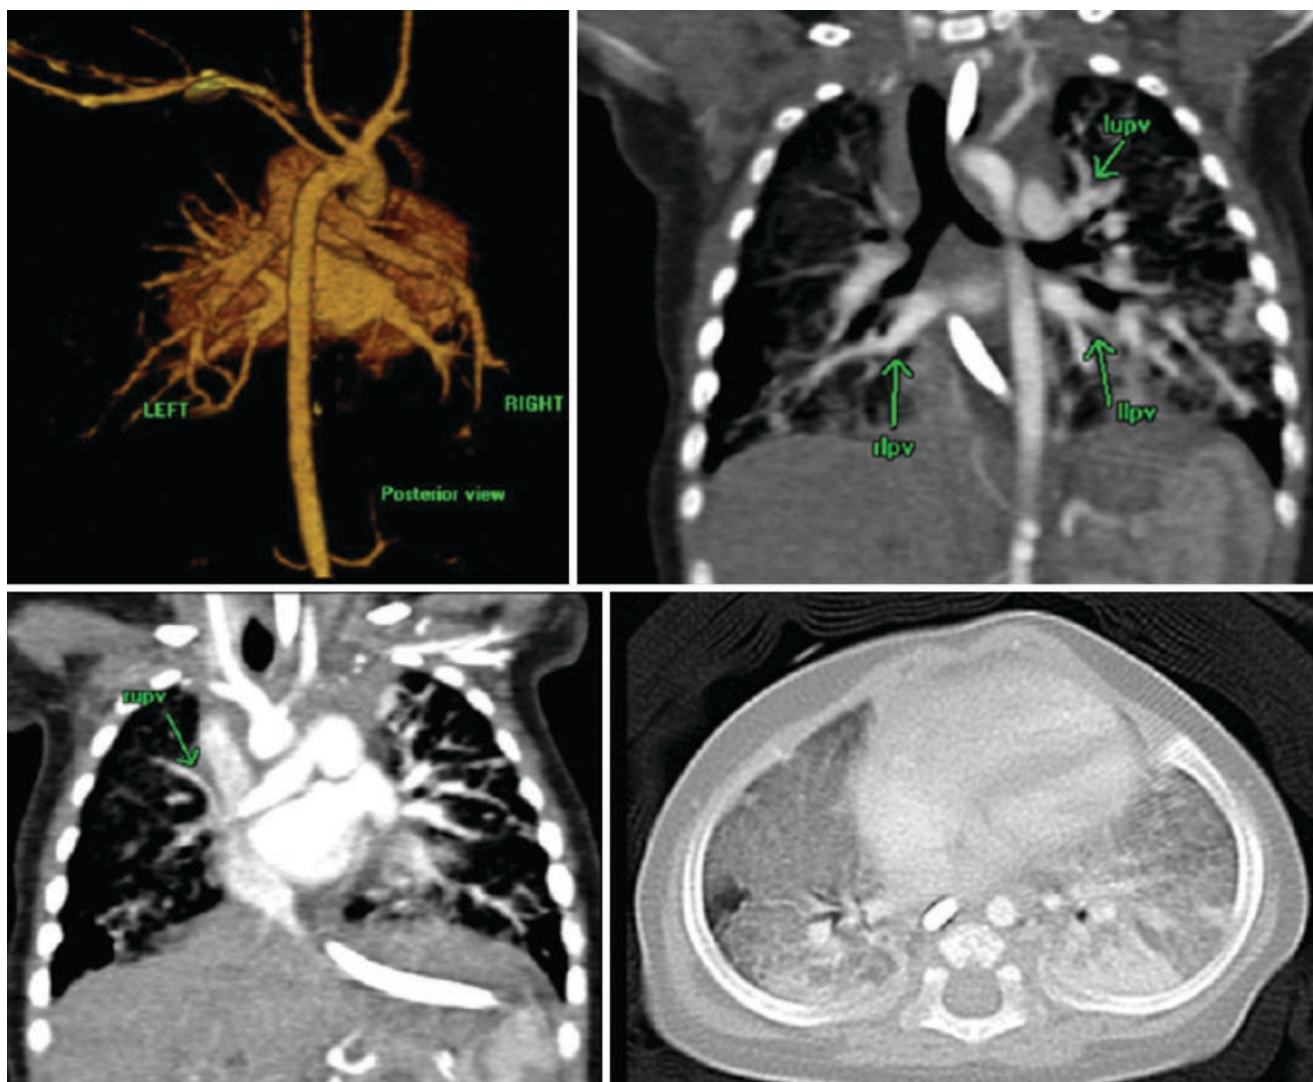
A 5-month-old boy, former 28-week gestation infant. Posterior view of 3D volume-rendered CT image, coronal soft tissue window CT images, and axial lung window CT image show a normal pulmonary venous anatomy but with a markedly narrowed right upper lobe pulmonary vein, which is moderately to severely stenotic just
